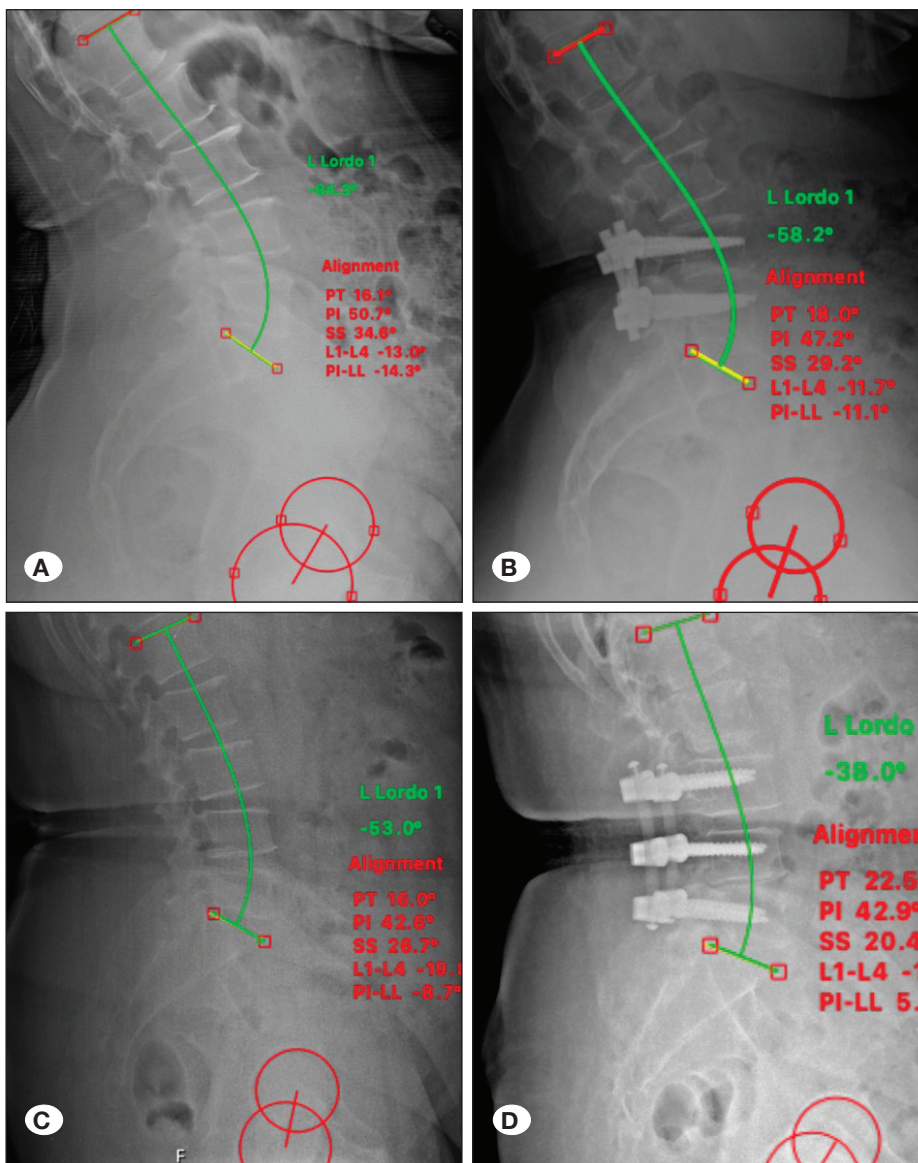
Preoperative and Postoperative Radiographs Showing Spinal Alignment in Patients Treated with PEEK and Rigid Rods. A) Preoperative image with severe lumbar lordosis (L1 Lordo -64.3°) and other alignment parameters PT 16.1°, PI 50.7°, SS 34.6°, L1-L4 -13.0°, PI-LL -14.3°. B) Postoperative image after surgery with Rigid rods, showing improved lumbar lordosis (L1 Lordo -58.2°) and reduced PI-LL mismatch (-11.1°). C) Preoperative image from a patient with lumbar lordosis (L1 Lordo -53.0°) and alignment parameters PT 16.0°, PI 42.6°, SS 26.7°, L1-L4 -19.1°, PI-LL -8.7°. D) Postoperative image after PEEK rod placement, showing further correction of lumbar lordosis (L1 Lordo -38.0°), with an increased PI-LL value of 5.4°.
